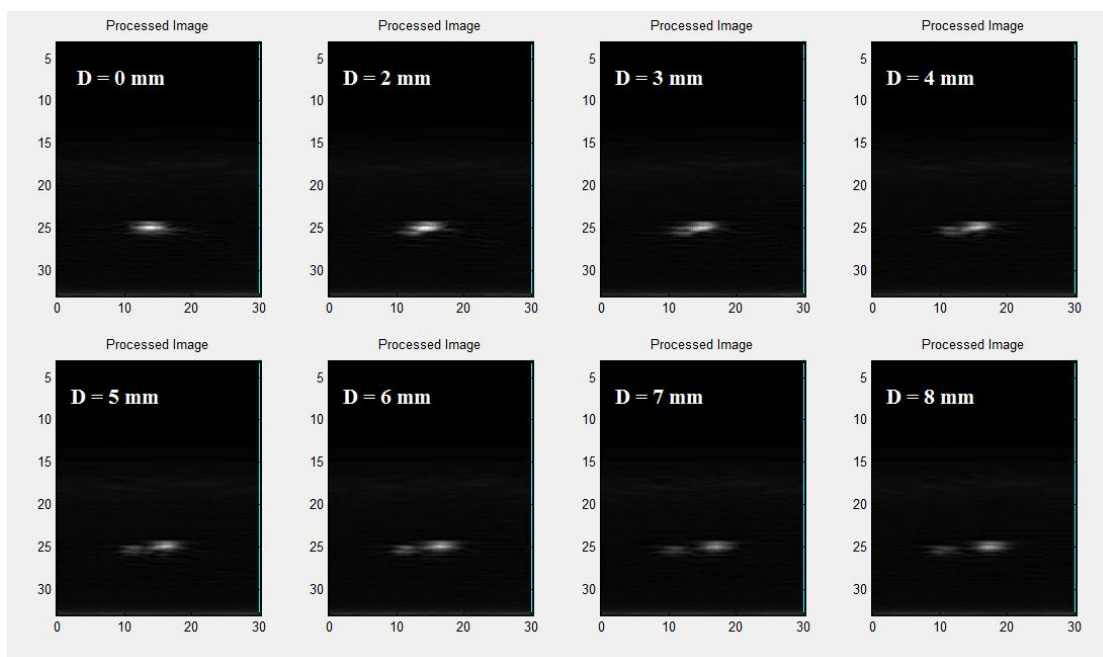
Elaborated images of two graphite rods in water. The actual displacement between the rods is indicated for each image and it is measured with the standard ultrasonic modality.
